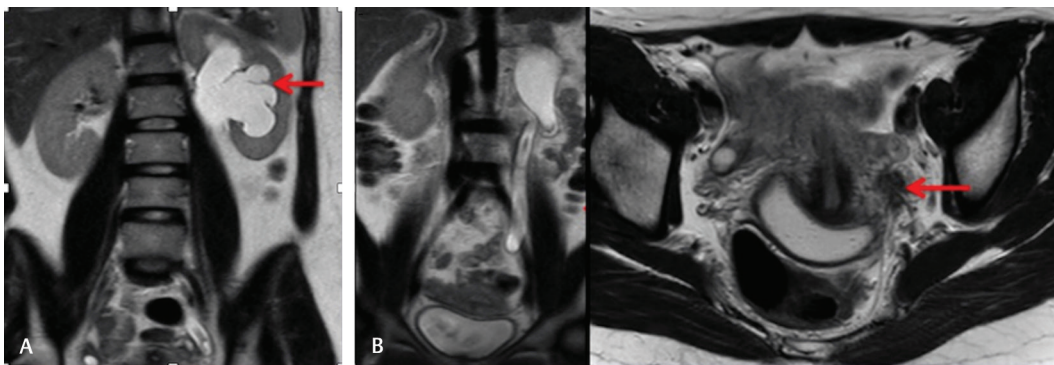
(A–C) Cor (A and B) and axial (C) T2W images showing left-sided hydronephrosis (arrow in A), hydronephrotic ureter (B), and a spiculated mass encasing the left ureter (arrow in C). T2W, T2-weighted.
